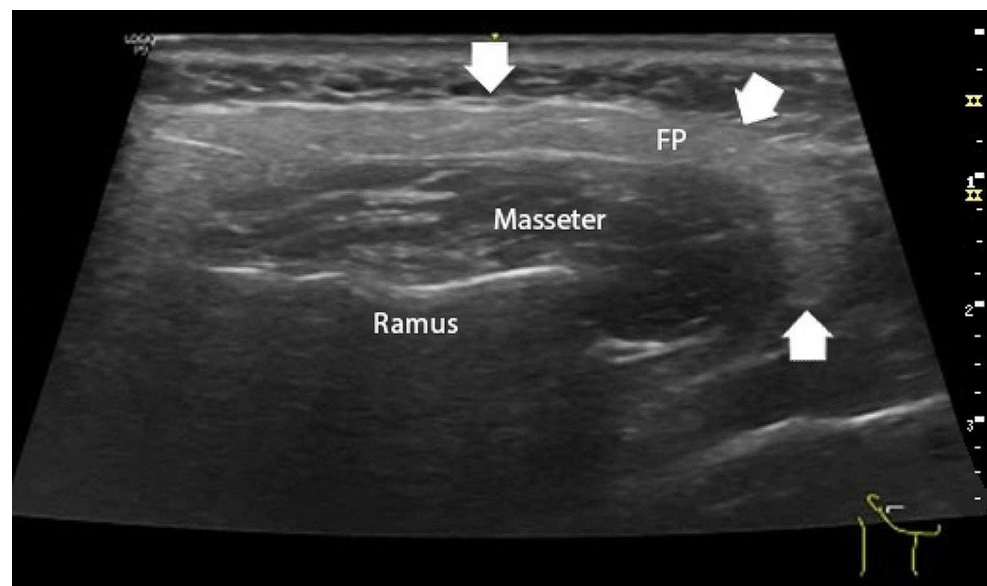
Ultrasonographic image of the APG (arrow)
